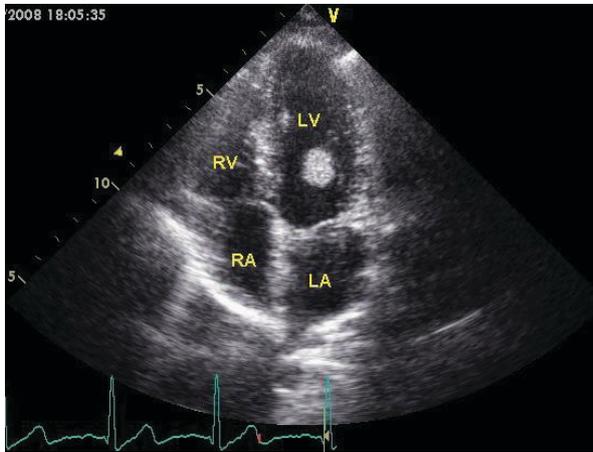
Appearance of left ventricular myxoma in parasternal axis view.
